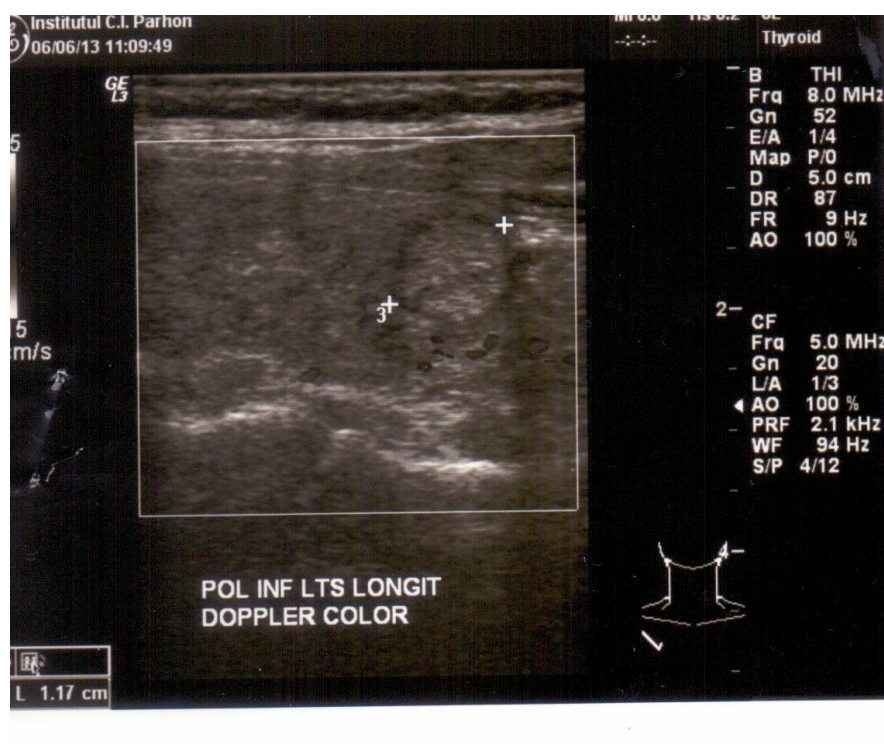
Thyroid ultrasound aspect of diffuse goiter.
